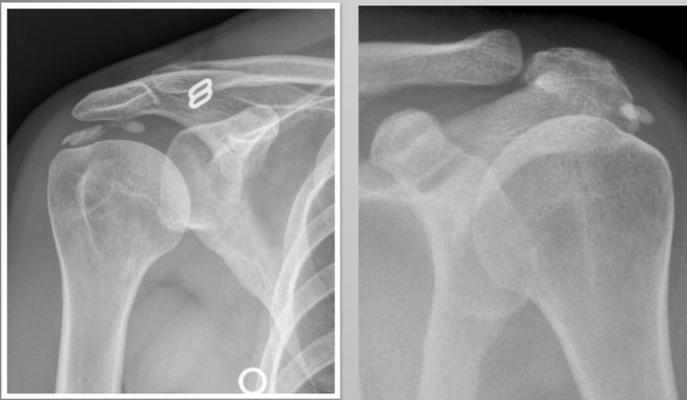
Right & left rotator cuff calcific deposits(Cdep) with clinical tendinosis, on x-rays
